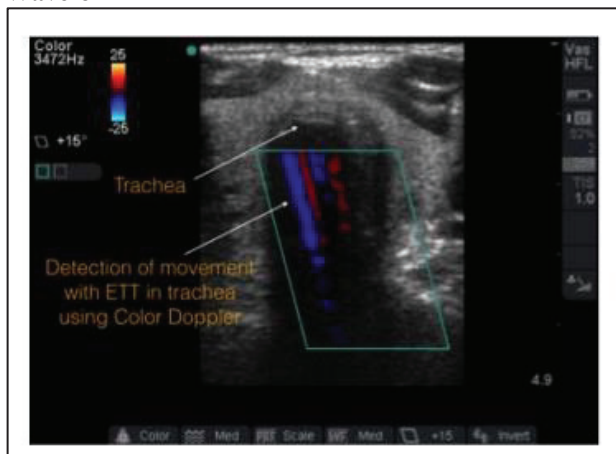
Detection Of The Endotracheal Tube Within The Trachea Using Color Doppler Imaging.
